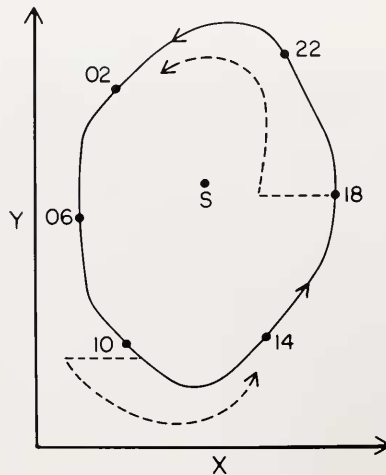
Limit cycle oscillator, depicting the relationship between the state variables X and Y in the phase plane. Time (or phase) in the circadian cycle is given by the circadian time points, 02, 06, 10, 14, 18, 22, which are successively encountered with counterclockwise motion around the stable limit cycle (solid line). The state variables in the membrane model are X = ion concentration and Y = ion transport, but other variables could be appropriate in other models. Perturbations of the oscillator with natural time givers or chemical pulses are shown here (CT 10 and CT 18) to reduce the X variable instantly, pushing the oscillator off the limit cycle. The oscillation (dotted lines) then approaches the limit cycle again but with a permanent phase advance (CT 18) or phase delay (CT 10). The amount of shift depends upon the strength of the perturbing stimulus. If the oscillator is driven to the singularity point(s) arrhythmia results until the oscillator is moved off the singularity. Adapted from Njus *et al.*, 1976, and Tyson *et al.*, 1976.
